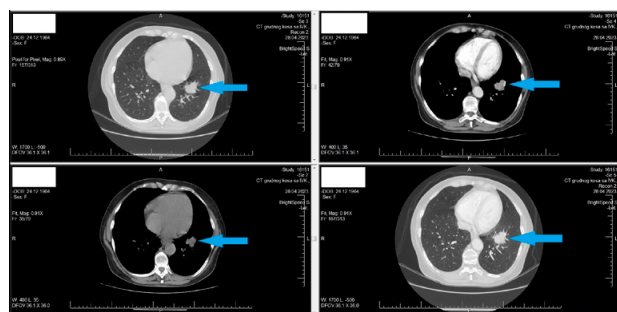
Chest computed tomography (CT), April 2023
